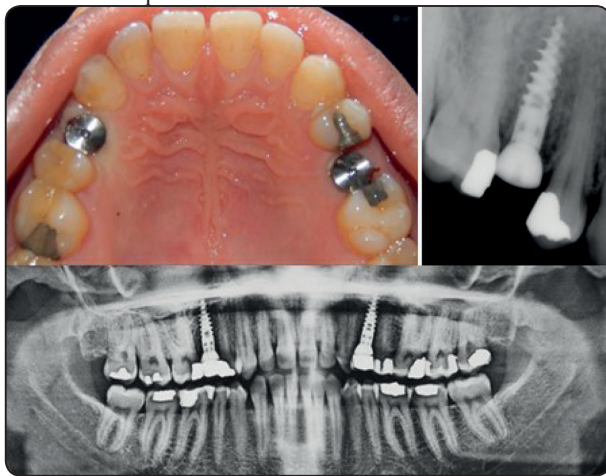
Postoperative evaluation. A: Clinical intraoral photograph, B: Digital. periapical radiograph and C: Panoramic radiograph
